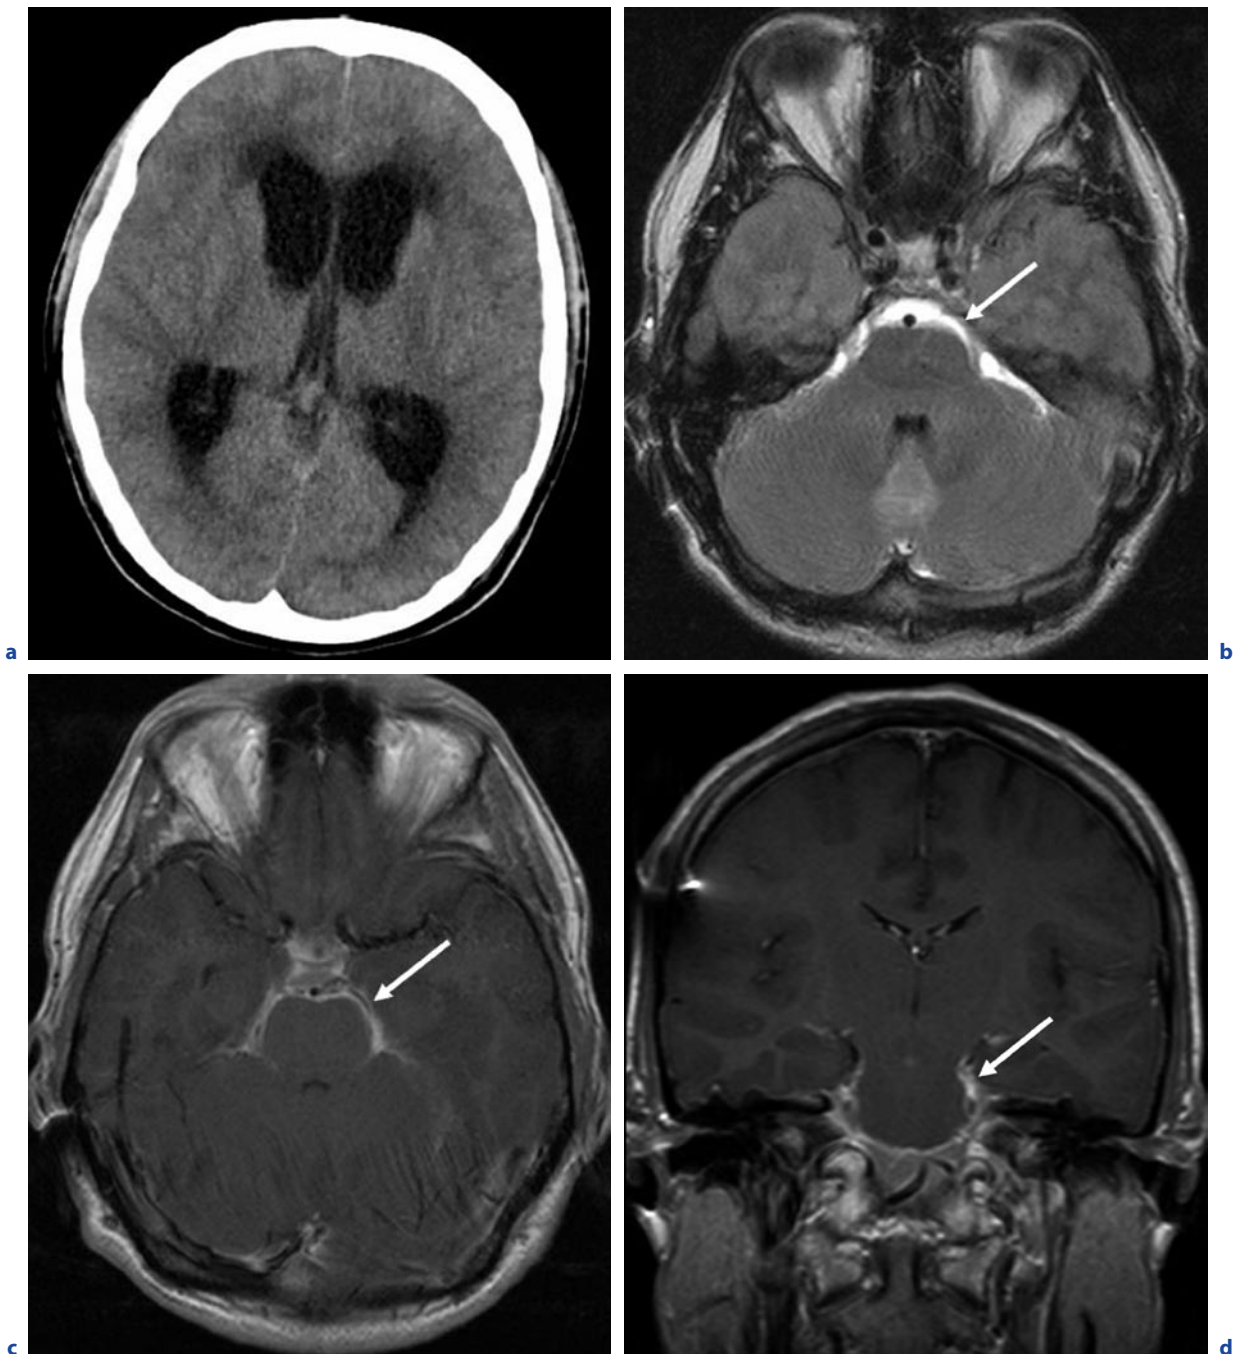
Tuberculous meningitis. A 24-year-old patient, with a history of intravenous drug abuse, presented with headache and abducent nerve palsy. a Axial CT. b Axial T2-weighted image. c Axial T1-weighted image after contrast administration. d Coronal T1-weighted image after contrast administration. Initial CT (a) showed hydrocephalus. MRI
